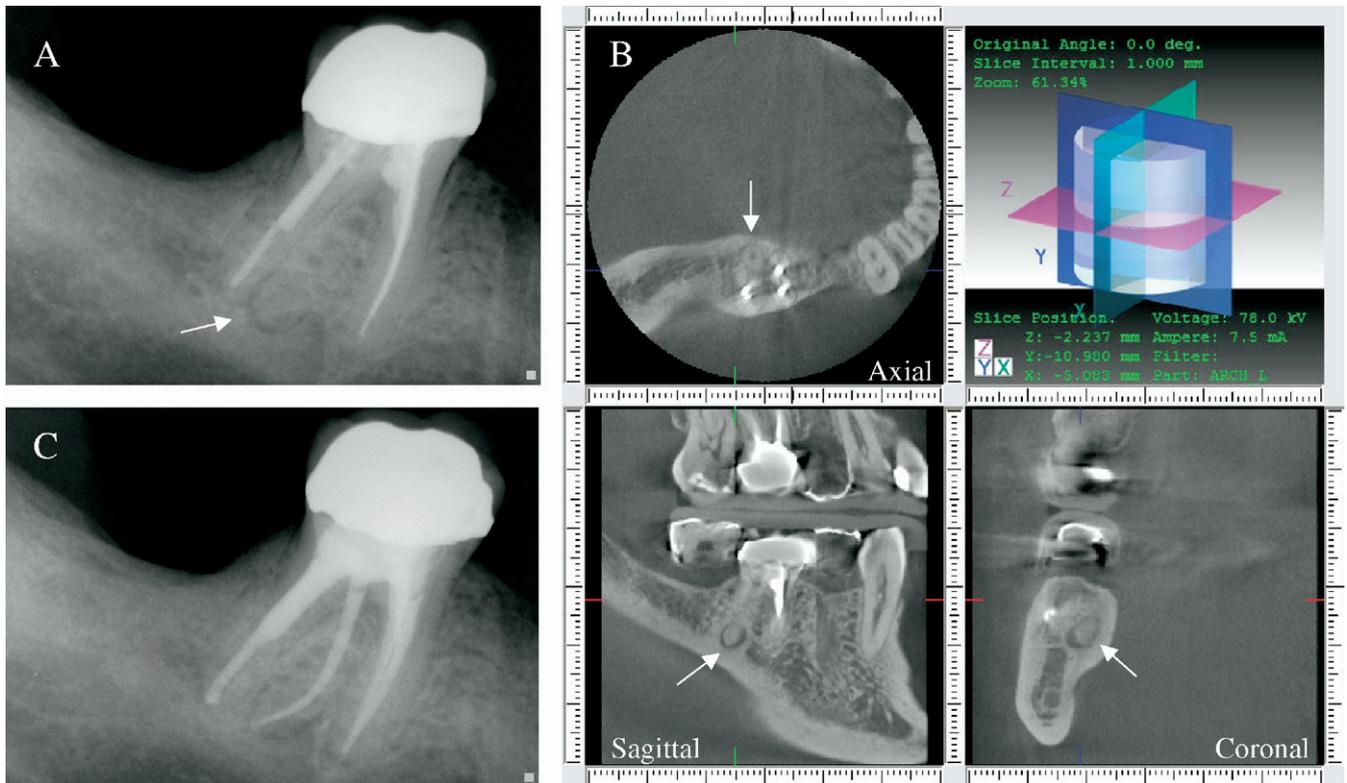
(A) Preoperative periapical radiograph depicts an undebrided distolingual root canal with a widened periodontal ligament space. (B) CBVT demonstrates axial, sagittal, and coronal 2-D slices of the undebrided distolingual canal and its associated periapical lesion. (C) Postoperative periapical radiograph of retreatment including obturation of the distolingual canal.
